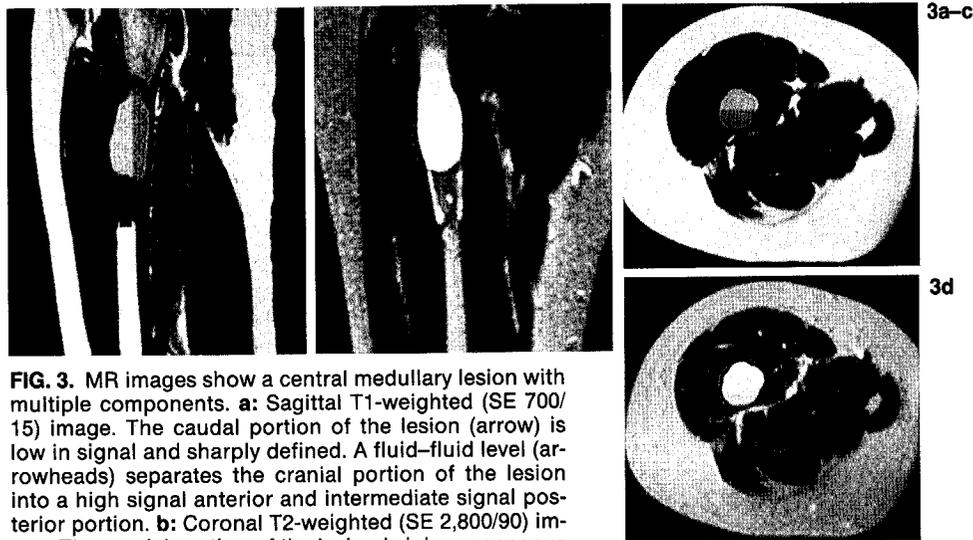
MR images show a central medullary lesion with multiple components. a: Sagittal T1-weighted (SE 700/15) image. The caudal portion of the lesion (arrow) is low in signal and sharply defined. A fluid-fluid level (arrowheads) separates the cranial portion of the lesion into a high signal anterior and intermediate signal posterior portion. b: Coronal T2-weighted (SE 2,800/90) image. The caudal portion of the lesion is inhomogeneous with both intermediate and high signal components. The cranial portion, with the coronal plane through the anterior part of the lesion seen in (a), is high in signal. c: Axial T1-weighted (SE 700/15) image. d: Axial T2-weighted (SE 2,800/90) image. These images (c and d) through the cranial portion of the lesion show the fluid-fluid level with the anterior portion being relatively high in signal on T1- and very high signal on T2-weighted images. The posterior component is intermediate in signal on T1- and high in signal on T2-weighted images.
